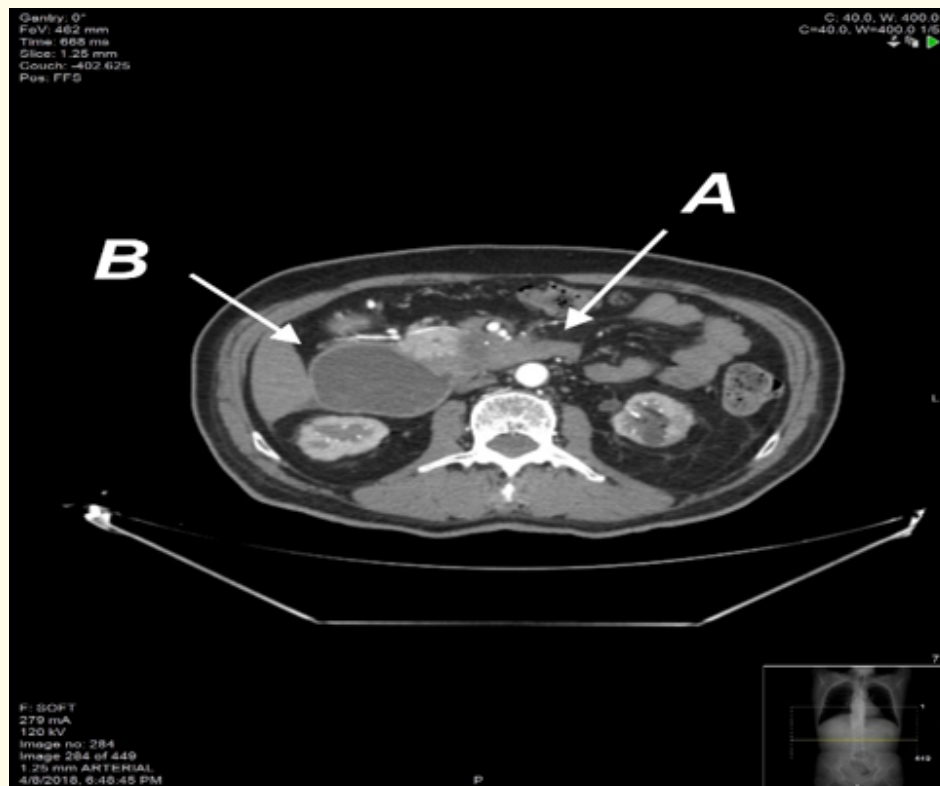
Emergency pre-operative CT Abdomen and pelvis with oral and IV contrast showing the pancreatic tumour (A) encapsulating superior mesenteric vessels and causing severe dilatation of the first part of the duodenum (B).
